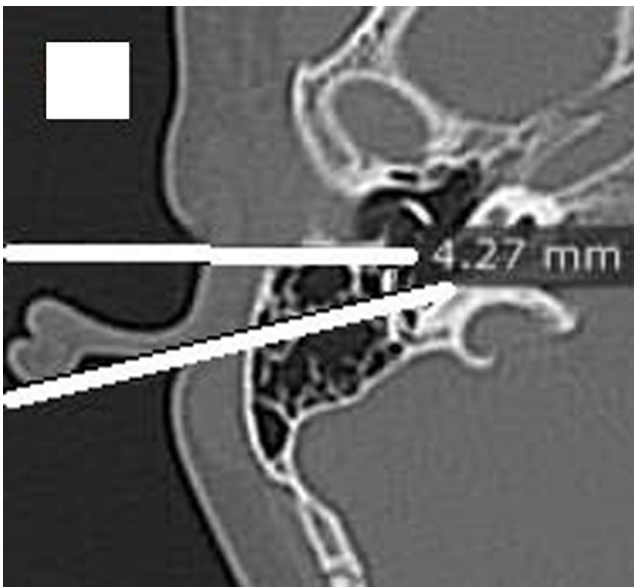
An axial cut of right temporal bone HRCT, showing the distance between the anterolateral surface of the mastoid segment of the facial nerve and the bony annulus of the posterior wall of the EAC (posterior tympanotomy width), was 4.27 which meant wide PT (it was scored 0 marks). HRCT, high-resolution CT scan.
